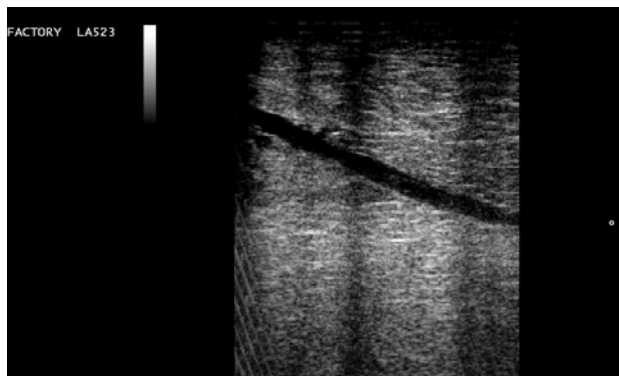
Ultrasonogram of udder showing anechoic venous congestion within the parenchyma.
